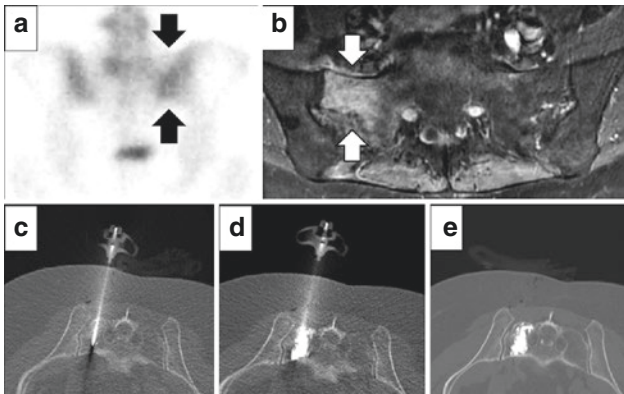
Insufficiency fracture of the right sacral ala causing significant weight-bearing pain ((a) bone scan with increased activity in the right sacrum, arrow, (b) MRI with contrast with increased intensity, arrow). Intra-procedural CT axial images during cementsoplasty, with needle placement in a posterior short-axis approach (c), followed by PMMA injection (d), and final procedure image with needle removed (e)
